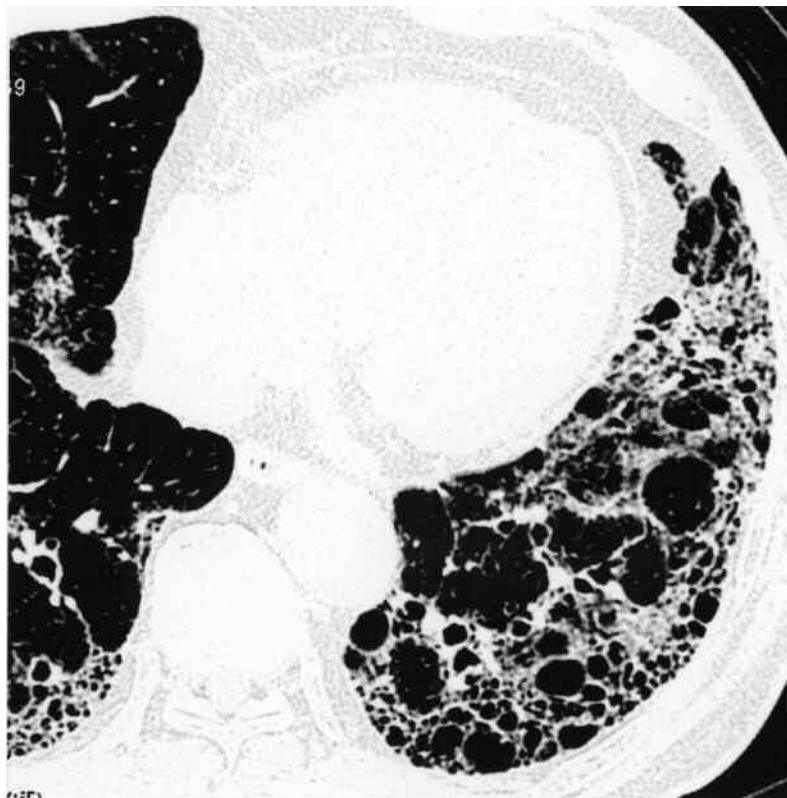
HRCT scan from a 71-year-old man with RA and the usual interstitial pneumonia (UIP) pattern. Reticulation and honeycombing are prominent in the peripheral and subpleural regions.
